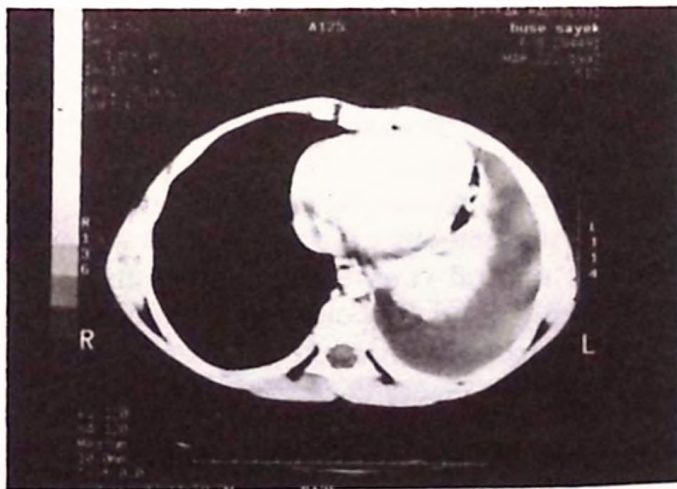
Axial computed tomography scan shows a large left-sided pleural effusion and passive atelectasis.
